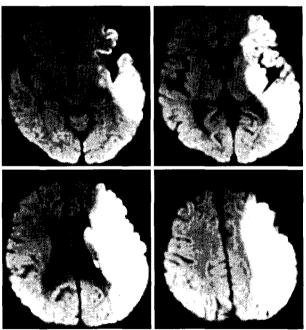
Brain diffusion magnetic resonance image showing diffusion restriction of the middle cerebral artery territory consistent with the cerebral infarction.
